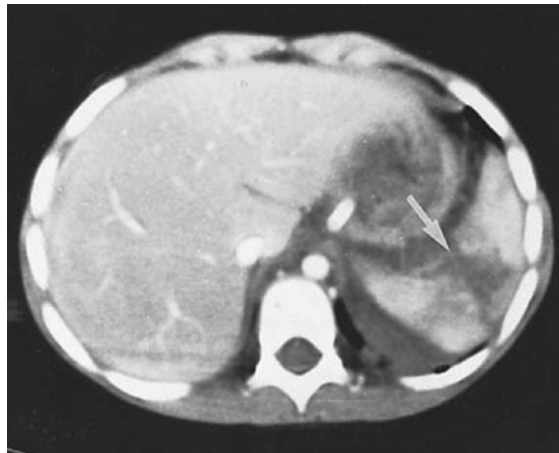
CT scan of the upper abdomen showing a ruptured spleen (arrow).
